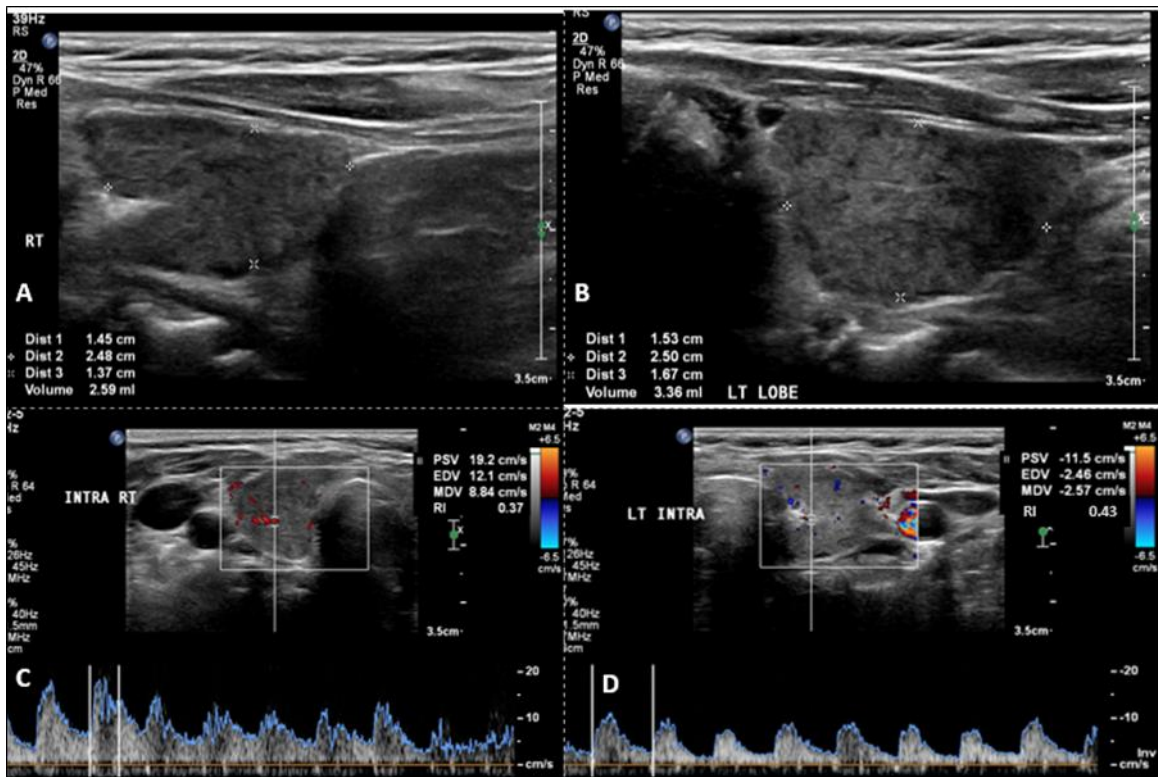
(A-D): In patient of chronic Hashimoto thyroiditis (A) & (B) shows small heterogeneous thyroid gland with progressive internal fibrosis and ill-defined margins suggestive of atrophy and (C) & (D) showing decreased vascularity on colour Doppler with spectral Doppler parameters
